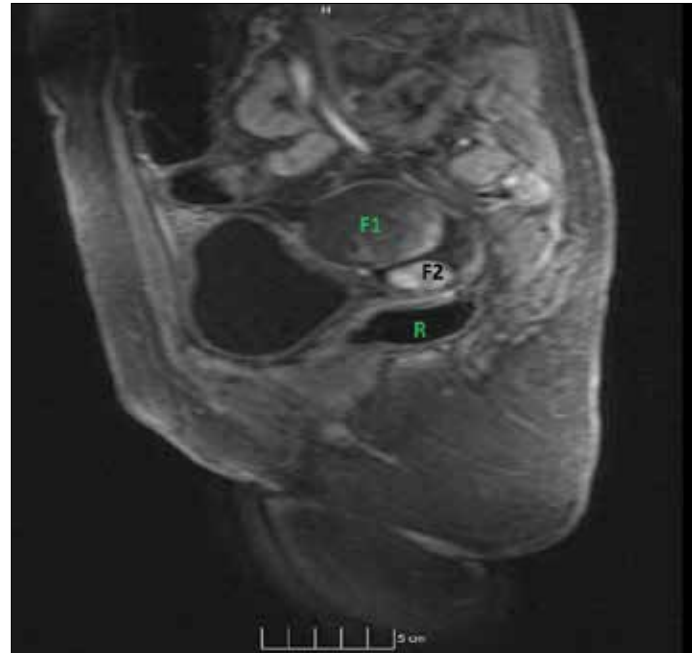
MRI with IV contrast (Panel C) showing an enhancement of the smaller fibroid (F2) but no enhancement of the larger fibroid (F1), suggestive of degenerative changes in the larger fibroid (F1)
